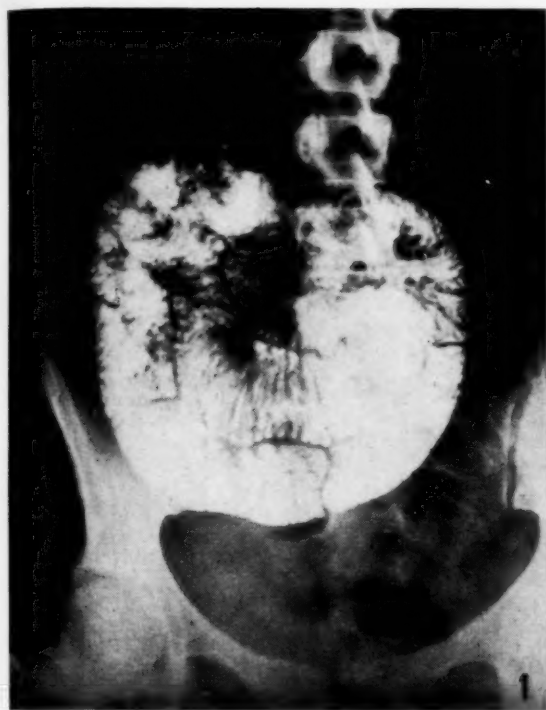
Barium-meal X-ray of a right paraduodenal-fossa hernia showing characteristic translucent 'paper bag' containing small bowel. This picture was published on a larger scale in the *Journal* (1954): 28, 516.¹
